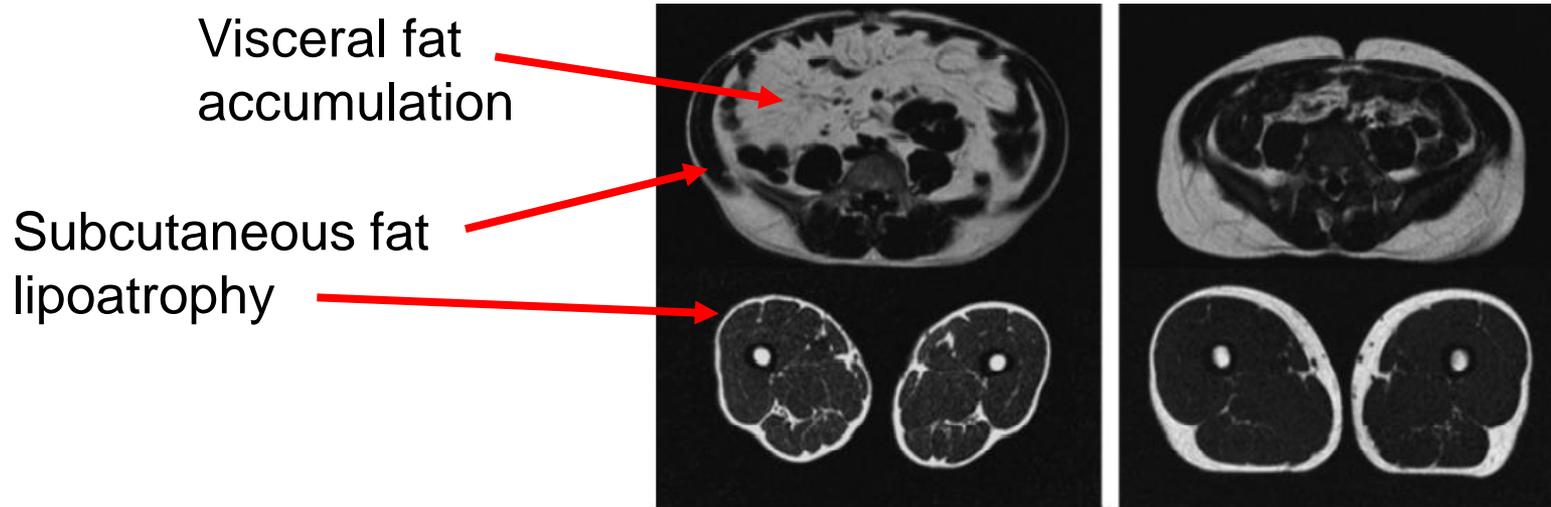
Representative magnetic resonance imaging (MRI) slices of the face, neck, abdomen and mid-thigh of an HIV-infected patient with a mixed type of lipodystrophy (left panel, a) and of an asymptomatic HIV-infected patient (right panel, b). Fat is displayed in light grey.
